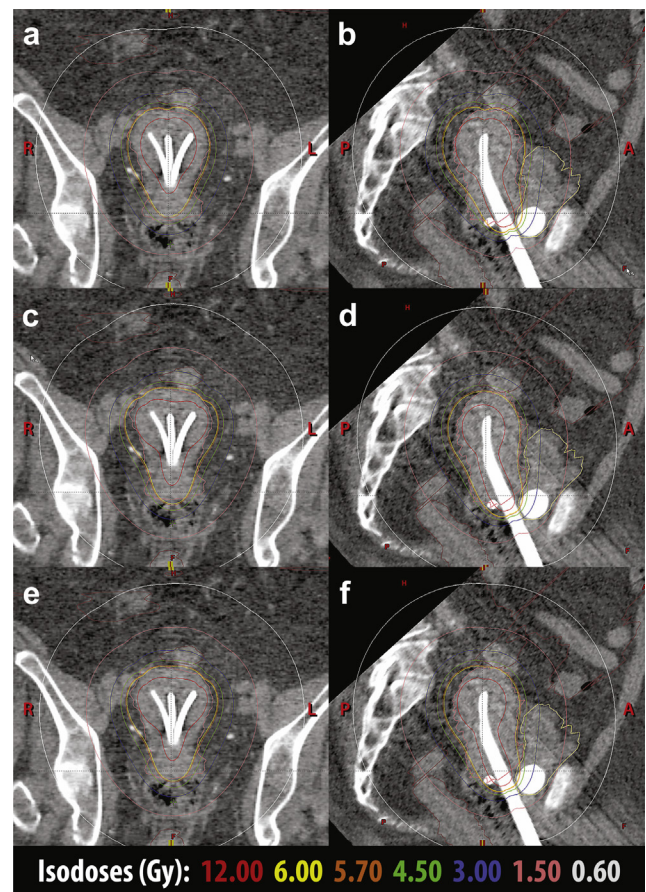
(a), (c), and (e) Paracoronar and (b), (d), and (f) parasagittal CT images, respectively, through the central tandem for Patient 1 using point-based planning based on a single (a, b), dual (c, d), and triple (e, f) tandem application.
